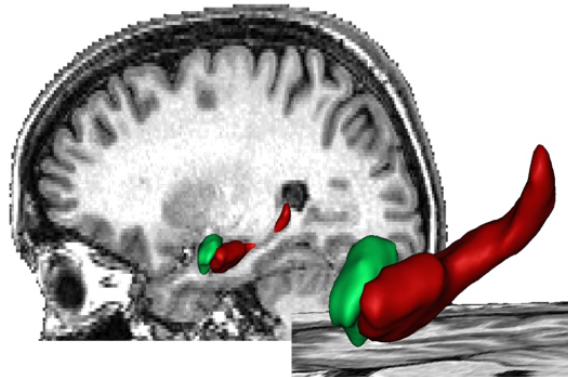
SACHA: automatic segmentation of the hippocampus and the amygdala from MRI ([Chupin et al., 2009b](#))
